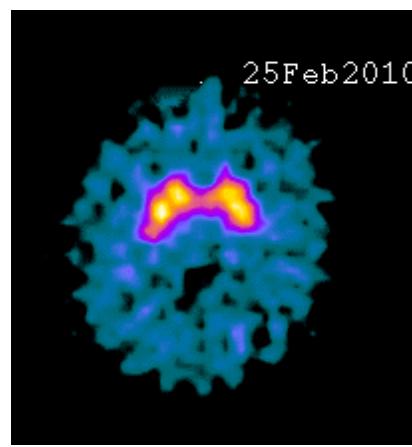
Normal ^{123}I -FP-CIT SPECT in patient with essential tremor
